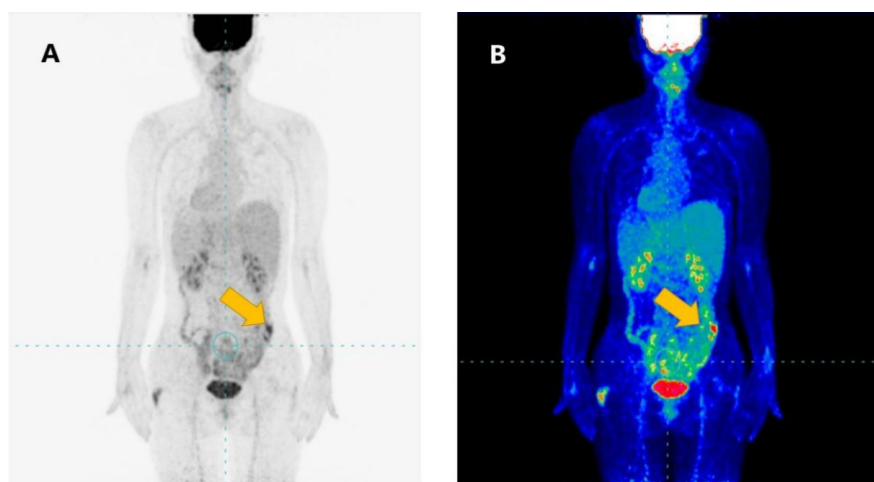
The (A) (B) chart shows the results of PET/CT examination: the change after Castlmen, and the arrows show the mild concentration of imaging agents in the surgical area, SUVmax5.3. Multiple lymph nodes in the retroperitoneal and left lateral iliac vessels had slightly larger lymph nodes, imagent distribution is slightly concentrated, SUV-max2.5.
